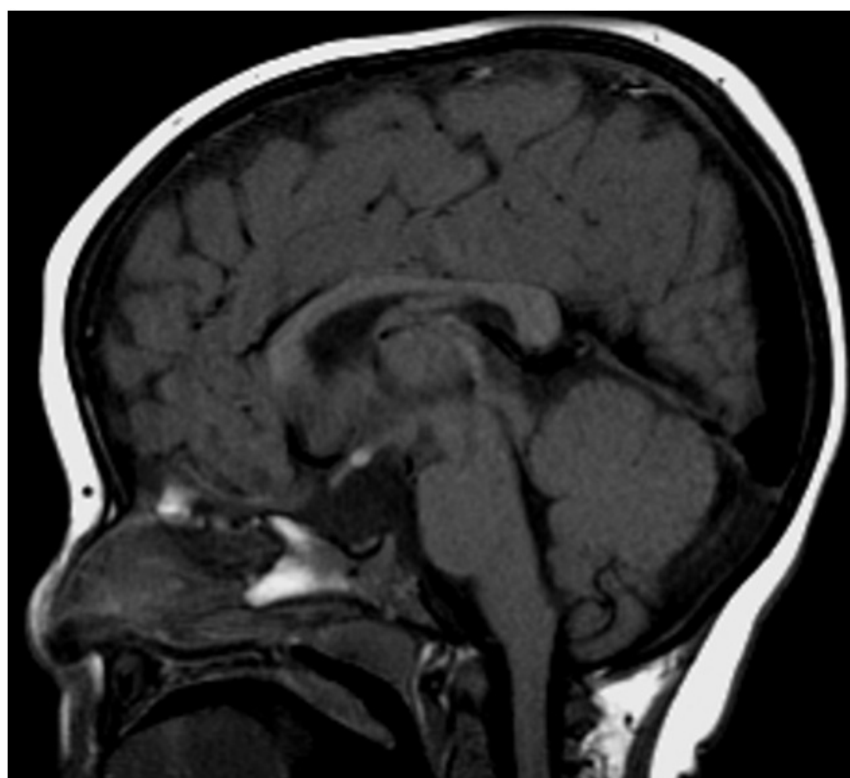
Sagittal T1 weighted Magnetic resonance imaging showing a small anterior pituitary, absent stalk, and normally located posterior pituitary.
